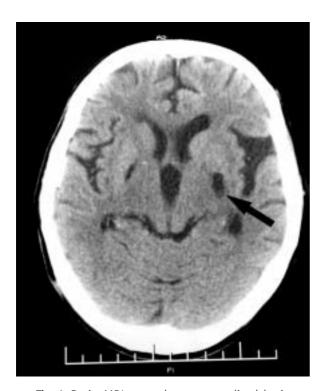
Brain MRI scan shows generalized brain atrophy, bilateral lacunas in the basal ganglia with postoperative change in the right globus pallidus (arrow), and small vasogenic foci dispersed in the white matter.
